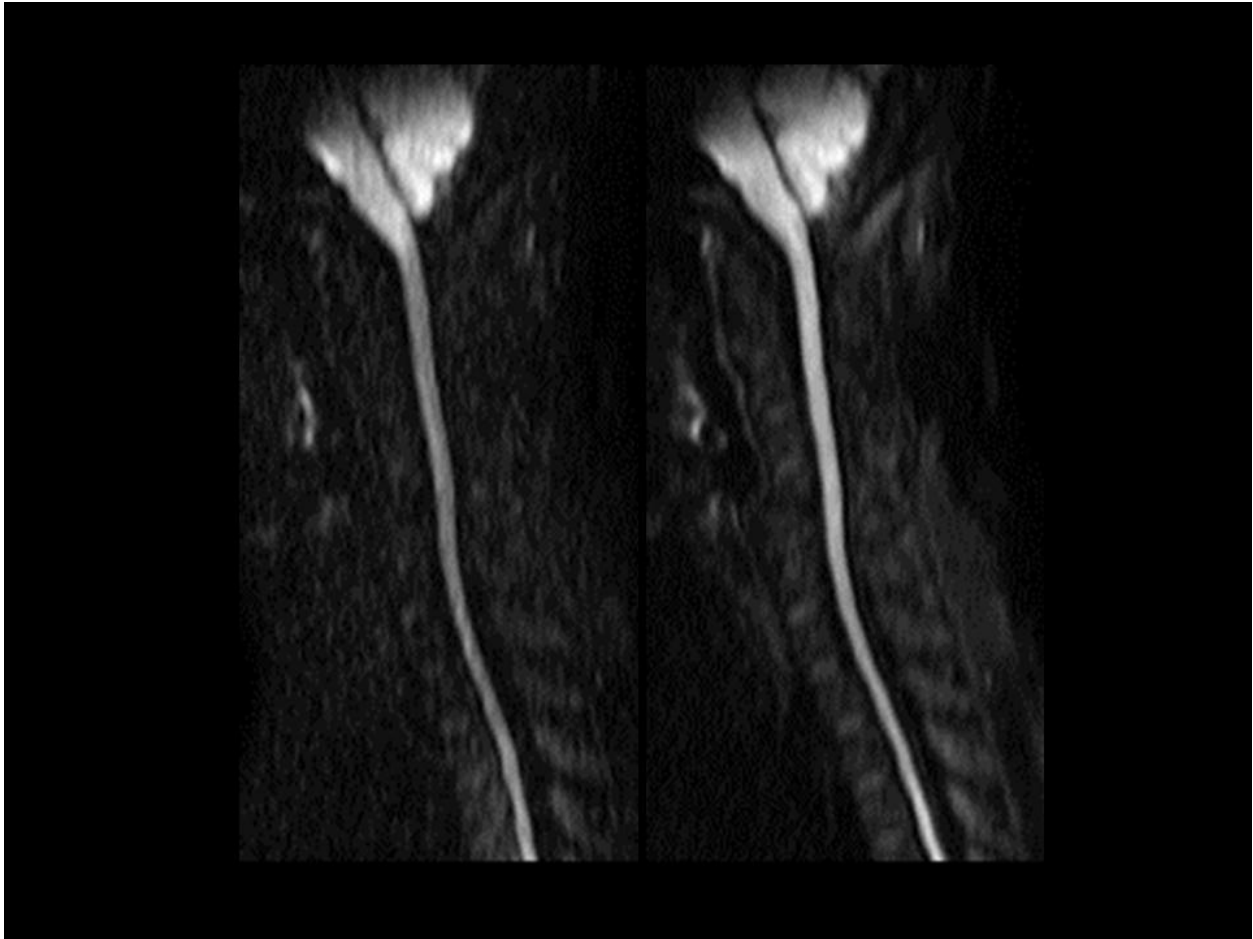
Enhancements to spine DWI. Note the improvement in speed, SNR and quality of depiction of the spinal cord when all 3 diffusion gradients are applied simultaneously (right, 3 in 1, scan time 0:38) when compared to the image obtained with traditional sequential (left, DTI 1:43) application . Both studies obtained at a PI factor of 2.
